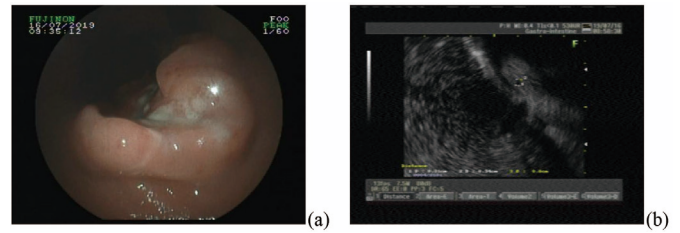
Preoperative gastroscopy (a) showed a huge irregular ulcer in the middle part of the gastric body, with white moss at the bottom; ultrasound, (b) showed that the focus is hypoechoic, the mucosa of all levels of the lesion is confused, and part of the serous layer is incomplete.
